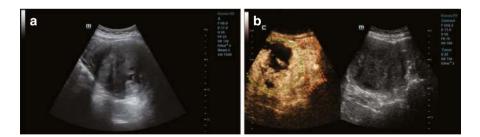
(a) B-mode ultrasound shows a solid mass within the uterus with poorly defined borders, heterogeneous hypoechoic patterns, and irregular fluid areas. (b) The contrast-enhanced ultrasound image shows that the tumor is heterogeneously hyper-enhanced, with nonenhanced areas. The tumor is circled in green; the uterus is outlined in orange.
